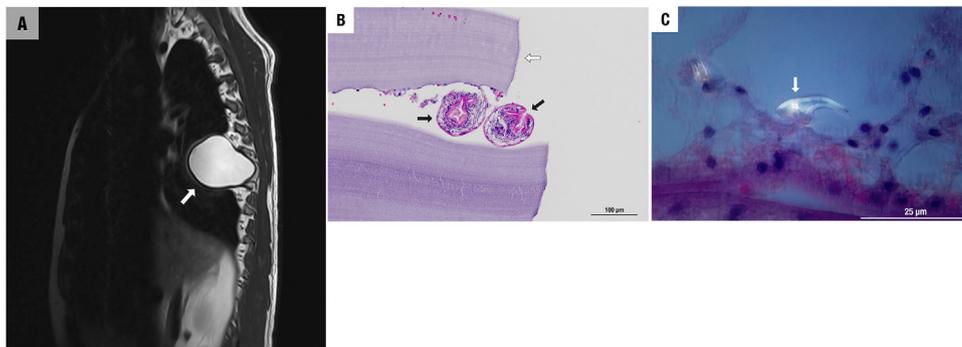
(A, T2-weighted MRI-scan); (B, hydatid cyst wall with attached protoscoleces); (C, Echinococcus hooklet).
